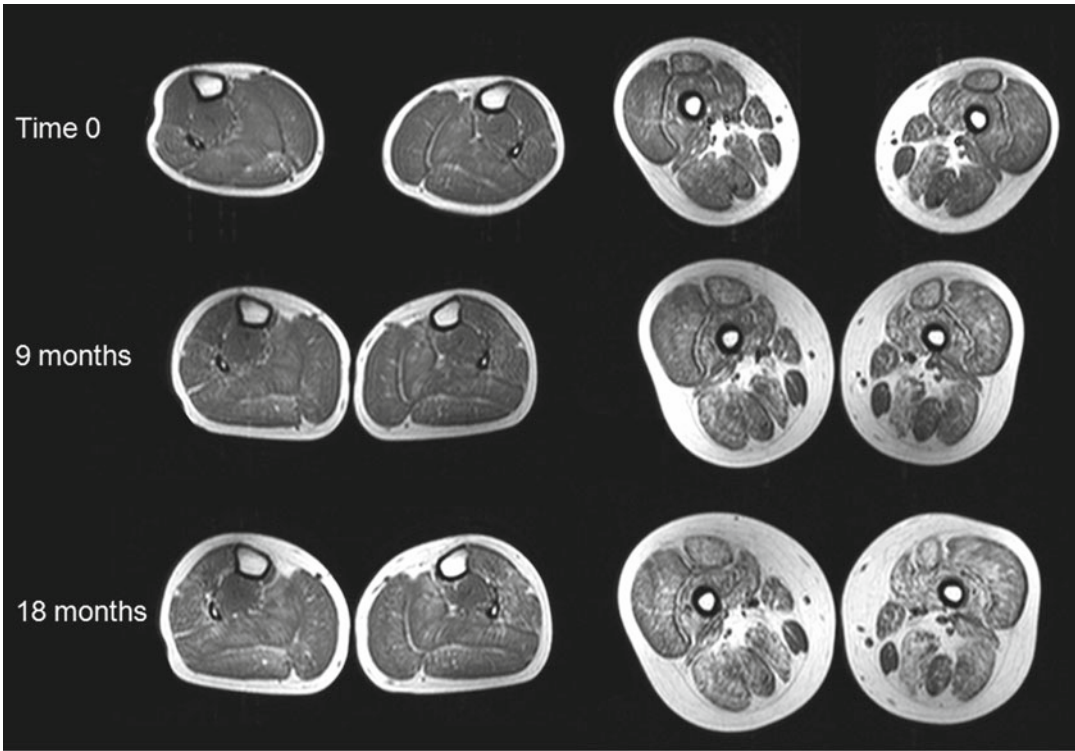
The axial T1-weighted MR images through the calves and thighs of a 6 years old (a) and an 8 years old (b) boy (age at time 0) with DMD show the progression of muscle pathology by MRI over a period of 18 months.
